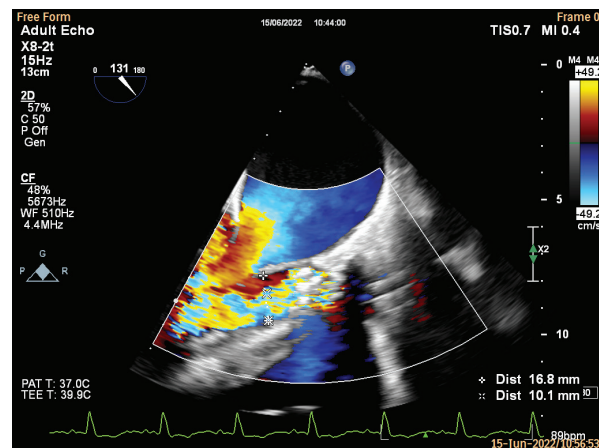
2D Color transoesophageal echocardiography – LAX moderate to severe aortic regurgitation due to aortic bioprosthesis malposition (AR/LVOT 60%)
